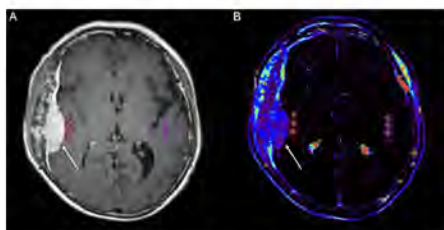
Axial postcontrast-T1-weighted image (A) demonstrates an avidly enhancing dural based mass along the right frontotemporal convexity and extending into the overlying calvarium (subsequently resected with pathology demonstrating CNS WHO grade 1 meningioma); subjacent (1) and contralateral (2) regions of interest are shown. Corresponding VE parametric map (B).
